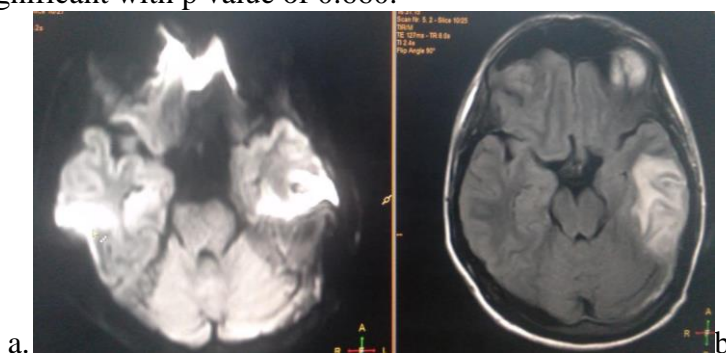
a.Axial DWI and B. Axial T2/ FLAIR sequences- T2/FLAIR hyperintensity showing DWI restriction in left parietal and left temporal lobe s/o infarct.
